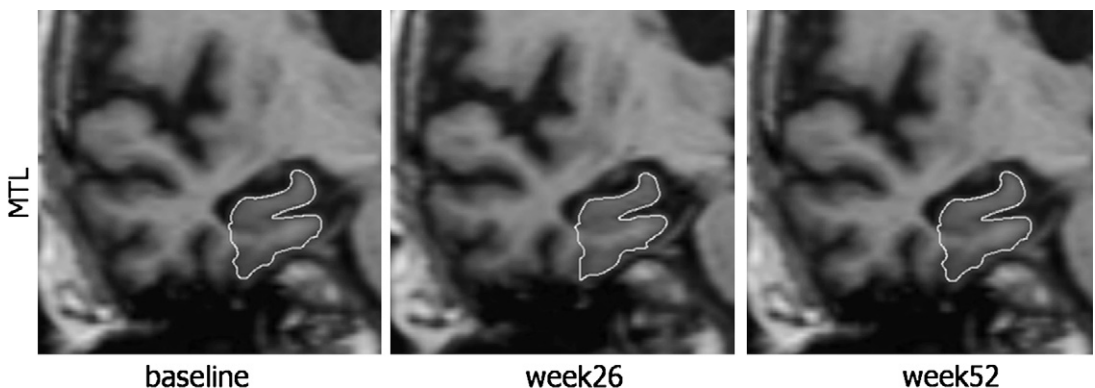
Measurement of medial temporal lobe (MTL) atrophy using manual segmentation on coronal T1-weighted scans.
